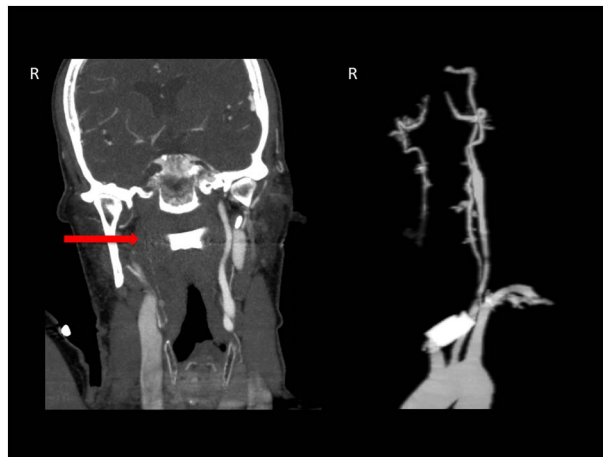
CTA showing right common and internal carotid artery occlusion (arrow, left panel; 3D right panel).
